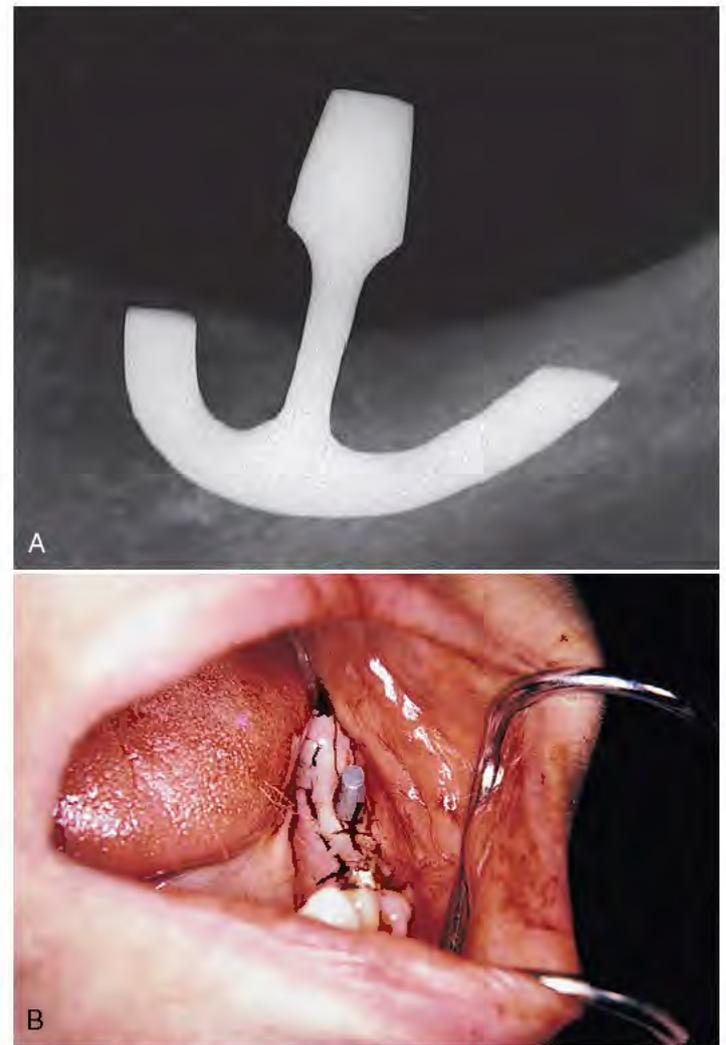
A, A postoperative radiograph is taken immediately to determine whether the implant is in the proper position. In this case, an additional osteotomy is indicated to allow deeper positioning of the implant. B, The most reliable form of closure for ridge crest incisions is the continuous horizontal mattress suture. Coaptation and primary healing are best facilitated when this technique is used.
